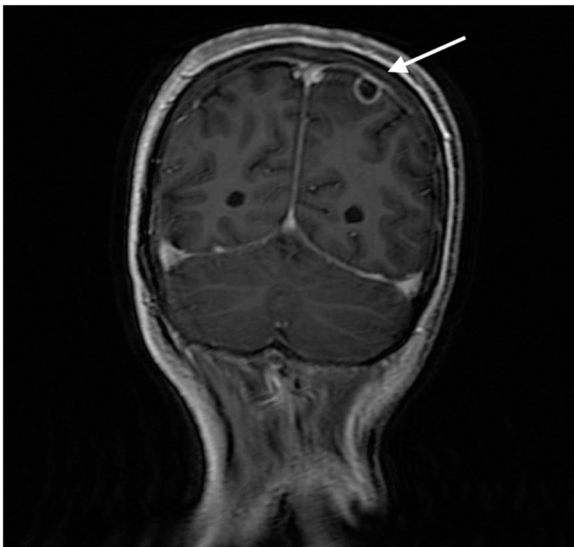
Coronal view of brain MRI showing rim enhancing lesion in left parietal lobe.
